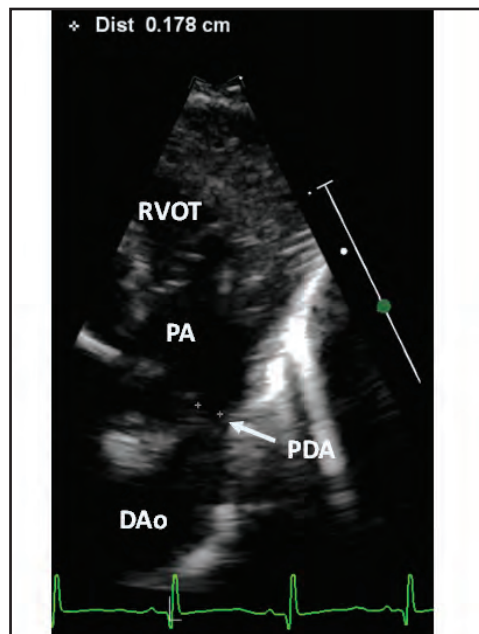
Selected video frame from modified parasternal short axis view (ductal view) demonstrating a Patent Ductus Arteriosus (PDA); 2-D measurement of the minimal ductal diameter (*Dist) is shown. DAo, descending aorta; PA, pulmonary artery; RVOT, right ventricular outflow tract.
